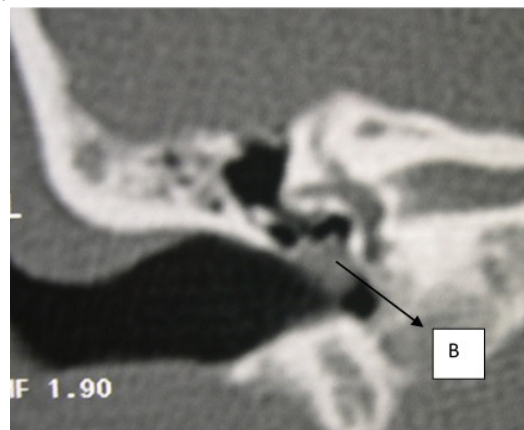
Computed tomography (CT) of the temporal bones : tissue density mass in left mesotympanum.
